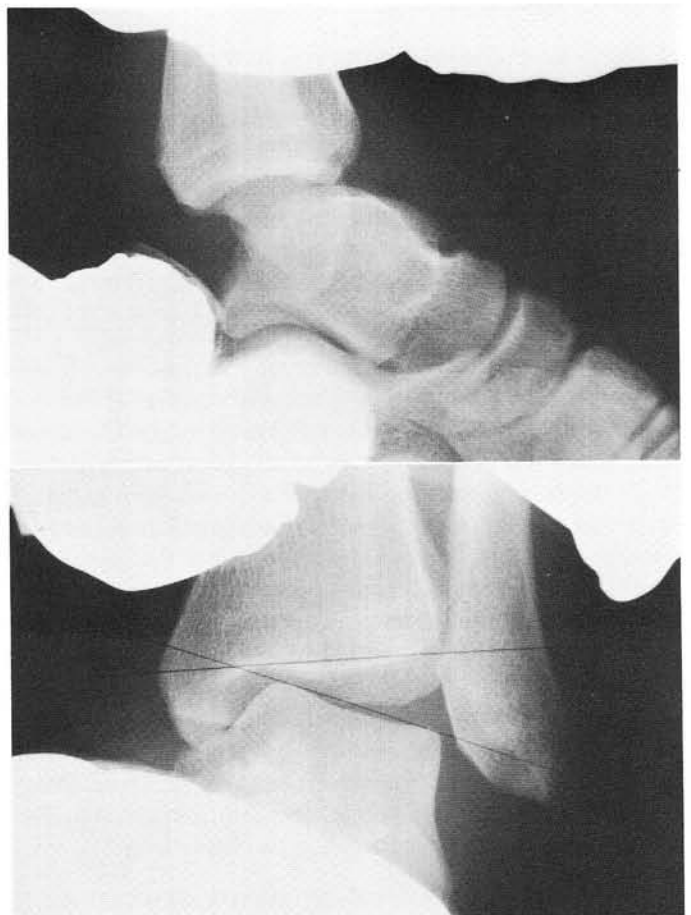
Stress radiography; positive anterior-drawer and inversion studies.
